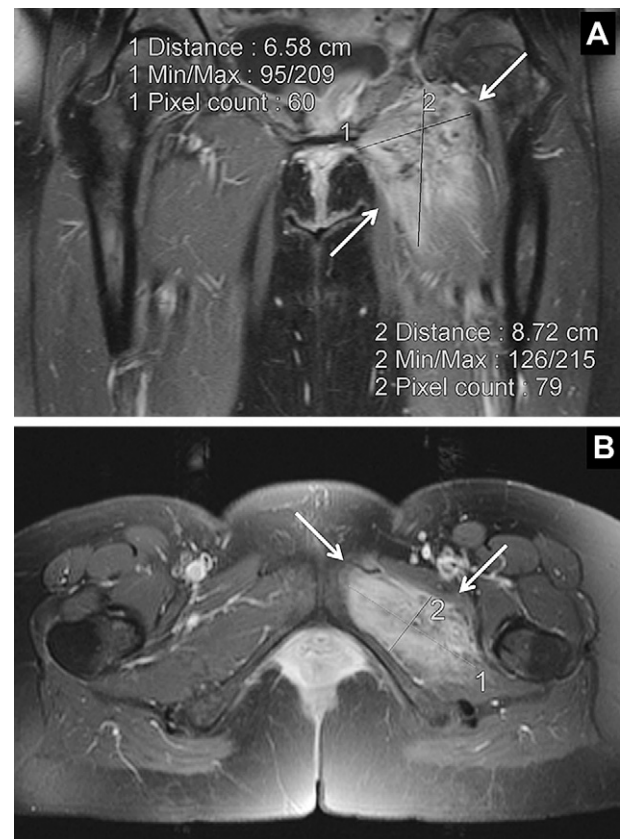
A, Fast spin-echo T1-weighted coronal post-contrast magnetic resonance image shows nonhomogeneous enhancement of an  $8.7 \times 6.6$ -cm adductor magnus muscle mass (arrows). B, Fast spin-echo T1-weighted axial magnetic resonance image with fat saturation, which confirms the post-contrast enhancement of the lesion (arrows).
